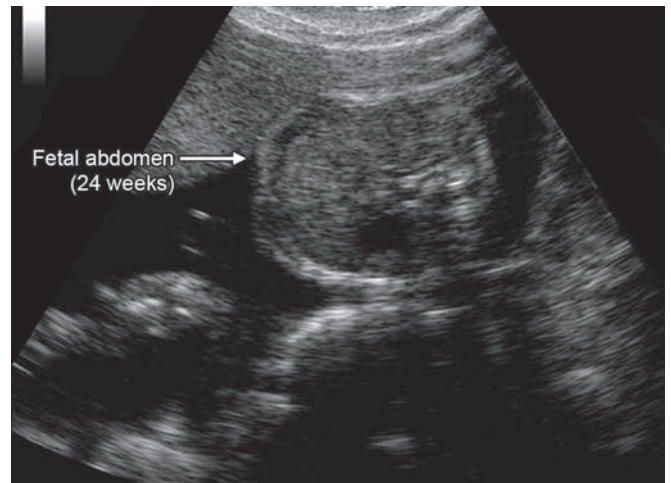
Ultrasound image of fetal abdomen (24 weeks)
